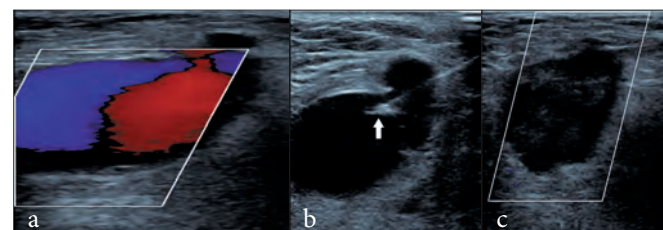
A larger pseudoaneurysm is confirmed on ultrasound (a). Percutaneous thrombin injection was performed. (b) Tip of the needle (closed arrow) positioned superficially within the aneurysm sac. (c) Complete haemostasis.
